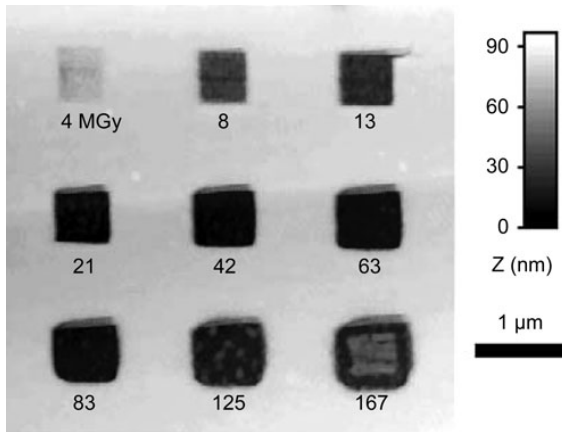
AFM image of the pattern directly written in PMGI with focused 300 eV monochromatic X-rays after development (the resolution of this image is equal to Fig. 1c)
